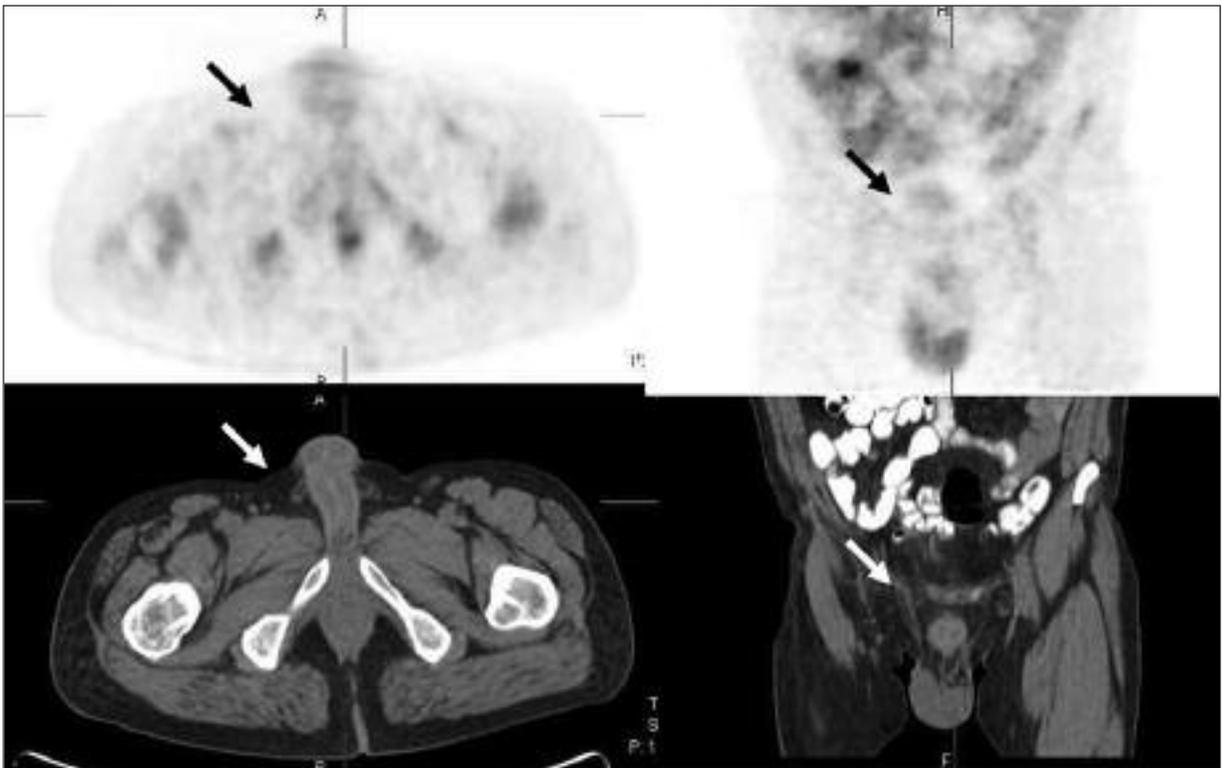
There is no increased activity at the same location with figure 1 A in the first FDG PET examination.
